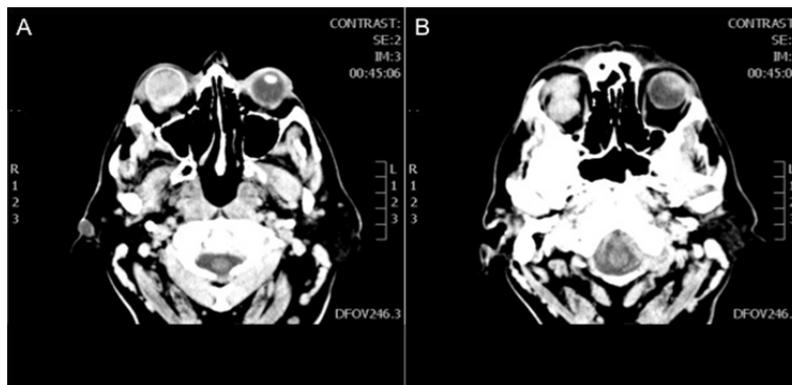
Magnetic resonance imaging of the skull showed bilateral hyperintense orbital masses (A) with an intraocular component (choroid) and extraconal component in the right eye (B)
